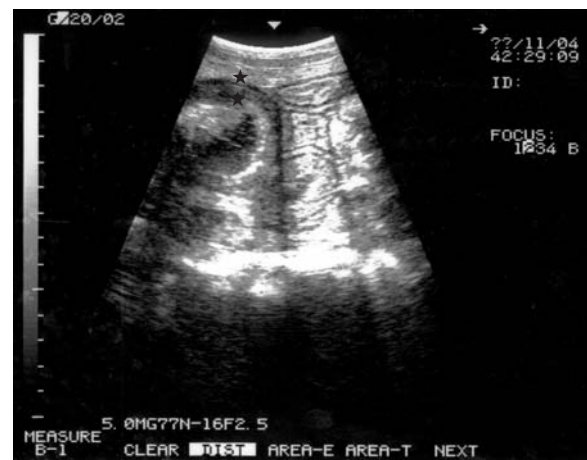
Ultrasonogram (5.0 MHz sector scanner) of the ventral abdomen of the 11-year-old Hackney pony. The jejunum is markedly thickened (0.5–0.8 cm, between *) in all segments visualised. Real time intestinal motility appeared to be normal and differences seen in luminal diameter are related to phase of contraction at the time of the image capture.
